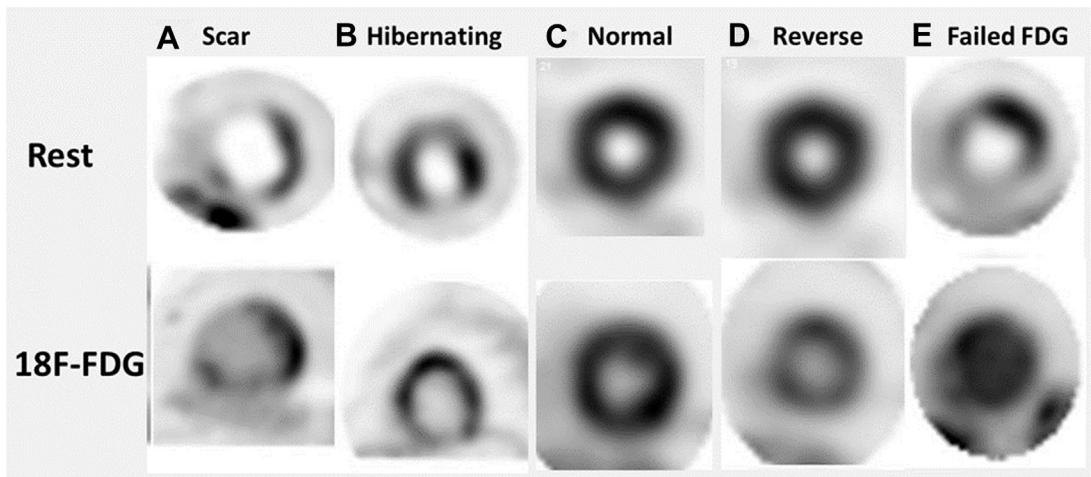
Four patterns of perfusion-metabolism. (A) Matched perfusion and metabolism, where both are abnormal. The presence of a resting perfusion defect with accompanying defect on FDG metabolic imaging signifies absence of viability and presence of scarred myocardium. There is a low likelihood this patient will experience improvement in LV dysfunction and adverse remodeling following revascularization. (B) Perfusion-metabolism mismatch involving the anterior wall, where a resting perfusion defect is accompanied by normal FDG uptake. This signifies the presence of viable, hibernating myocardium in the anterior wall. This patient has a high likelihood of experiencing improvement in LV systolic function and adverse remodeling following revascularization. Also note the presence of a matched perfusion-metabolism defect involving the inferior wall, which denotes scar. (C) Matched perfusion and metabolism where both are normal. This denotes normal myocardium at rest. If the patient experiences chest pain, angina, or other symptoms suggestive of ischemia, ischemia assessment should be considered. (D) Perfusion-metabolism mismatch, where there is no resting perfusion defect, but there is accompanying reduction in FDG uptake. This usually is seen in patients with left bundle branch block as a mismatch in the interventricular septum and also has been described in patients with stunning or significant insulin resistance. (E) Example of patient with high insulin resistance and poorly controlled diabetes mellitus resulting in poor-quality FDG images precluding accurate viability assessment.
